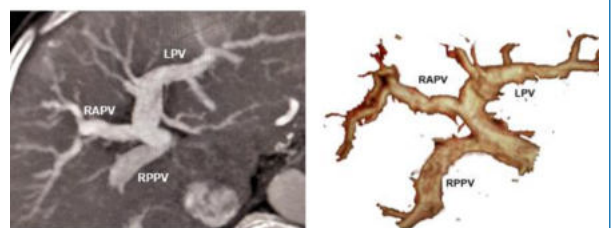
CT axial reformatted MIP and VR image in the portal venous phase showing RAPV branches from the Left portal vein
